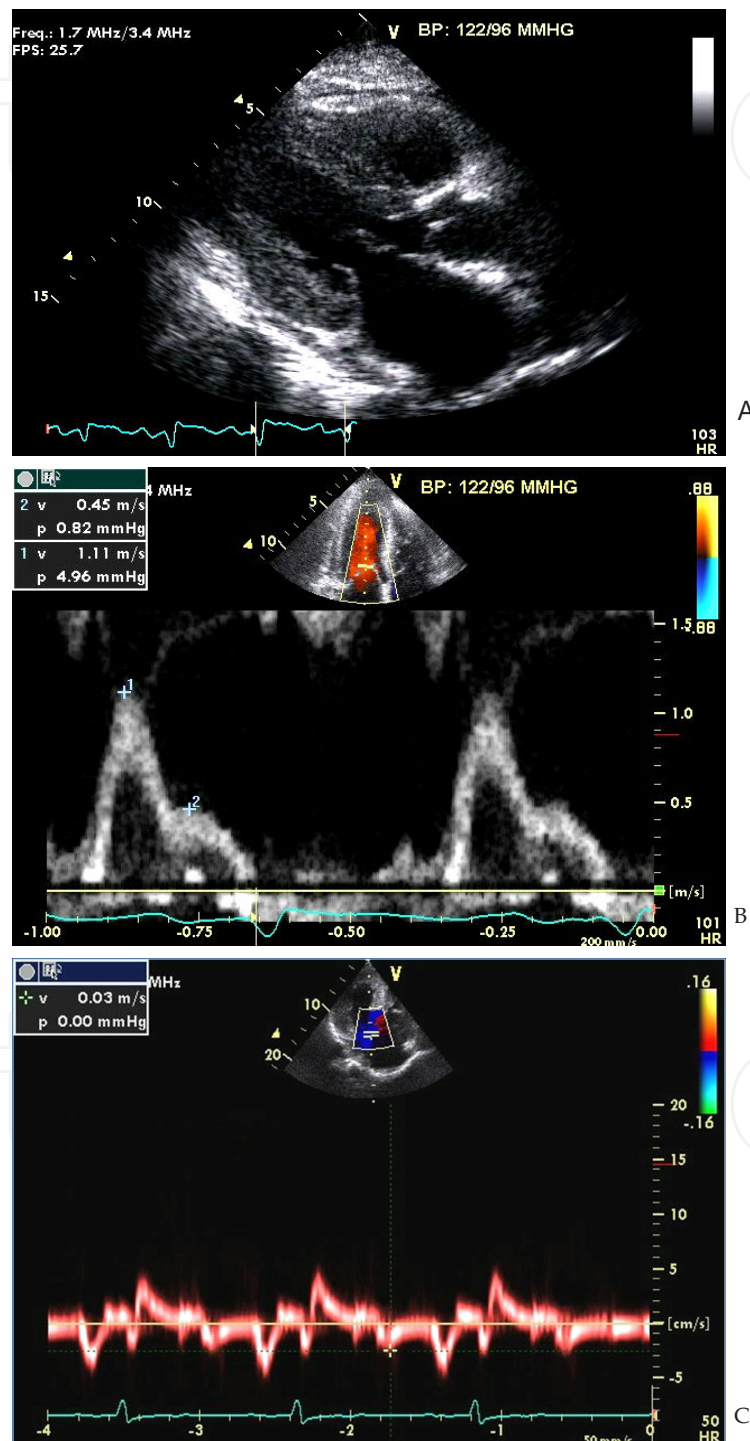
(A) Two-dimensional echocardiographic, (B) transmitral Doppler and (C) tissue Doppler images classical of AL amyloidosis.
